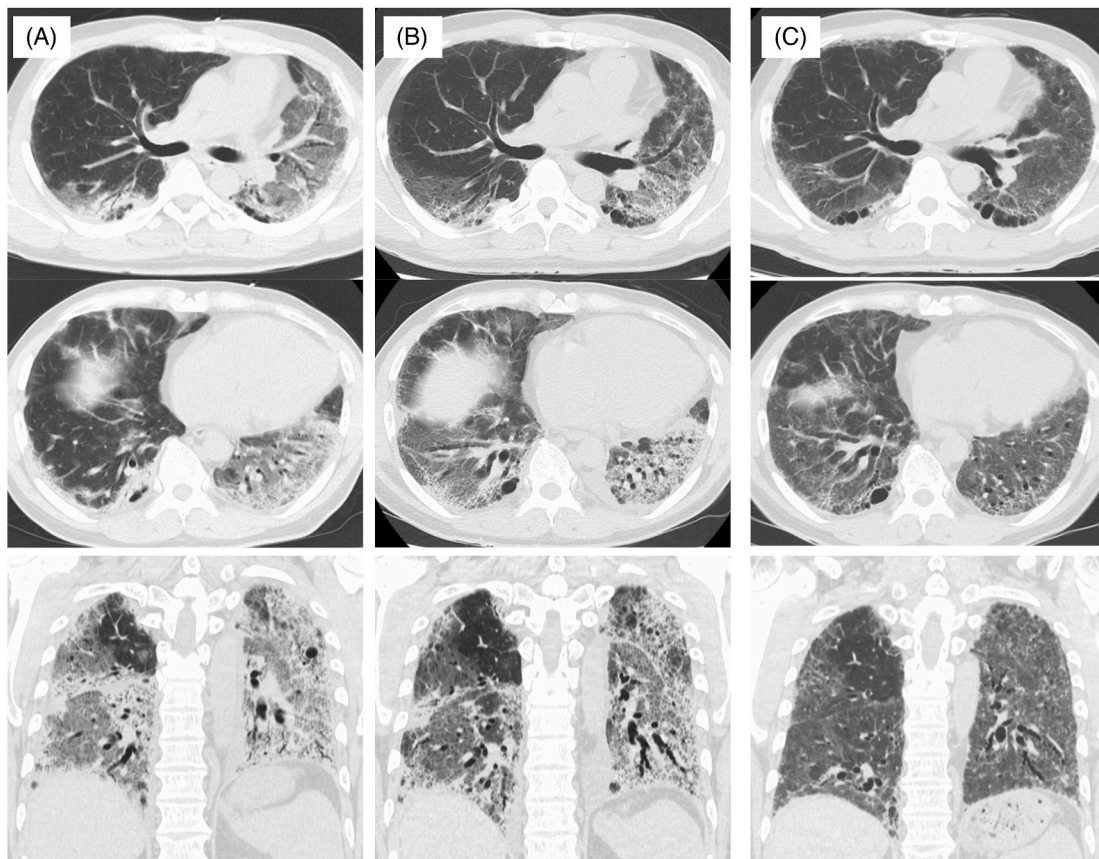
Chest CT images of the patient. (A) On admission to the first hospital (day 1), chest CT images showed consolidations and ground-glass opacities (GGO), predominantly in the bilateral lower lobes with loss of lung volume, suggesting a radiologic pattern of diffuse alveolar damage (DAD) superimposed on non-specific interstitial pneumonia (NSIP). (B) On admission to Hamanomachi Hospital (day 11), chest CT images showed progression of the areas of GGO, consolidations, traction bronchiectasis, and decreased lung volume. (C) On day 40, chest CT images showed improvement of GGO and consolidations. Traction bronchiectasis in the peripheral area and loss of lung volume were partially reversed as well.
